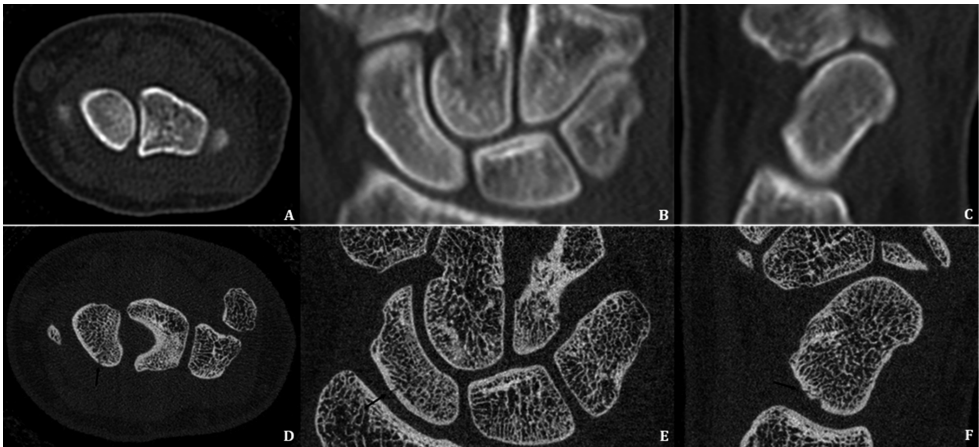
A 25-year-old woman with a type-B3 scaphoid fracture that was diagnosed on HR-pQCT scans. A-C) Transverse (A), coronal (B), and sagittal (C) CT slices that were negative for scaphoid fracture. D-F) Transverse (D), coronal (E), and sagittal (F) HR-pQCT scans that were positive for scaphoid fracture (arrows).
